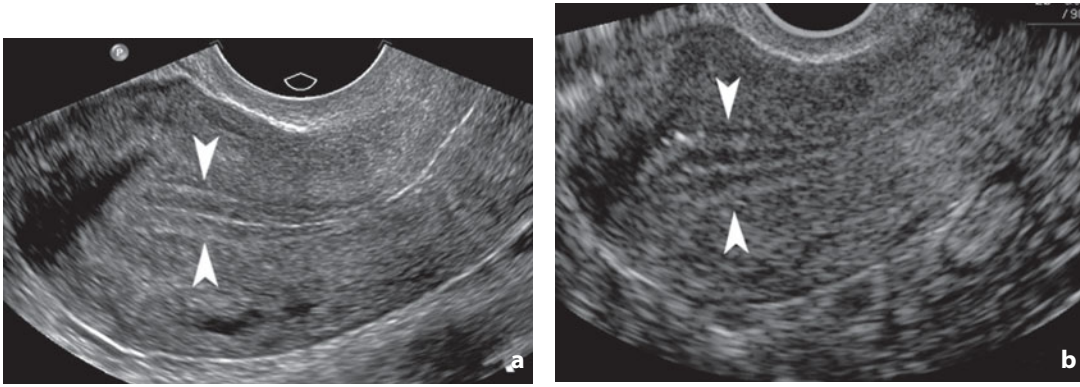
Transvaginal ultrasonography. Uterus. Longitudinal scans. Examples of follicular phase. The images show the trilaminar appearance of the endometrium between the *arrowheads*
